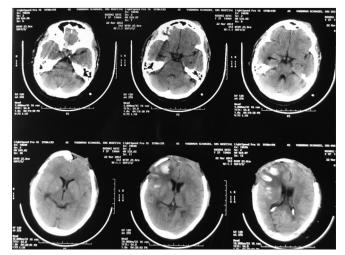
Postoperative computed tomography scan head
